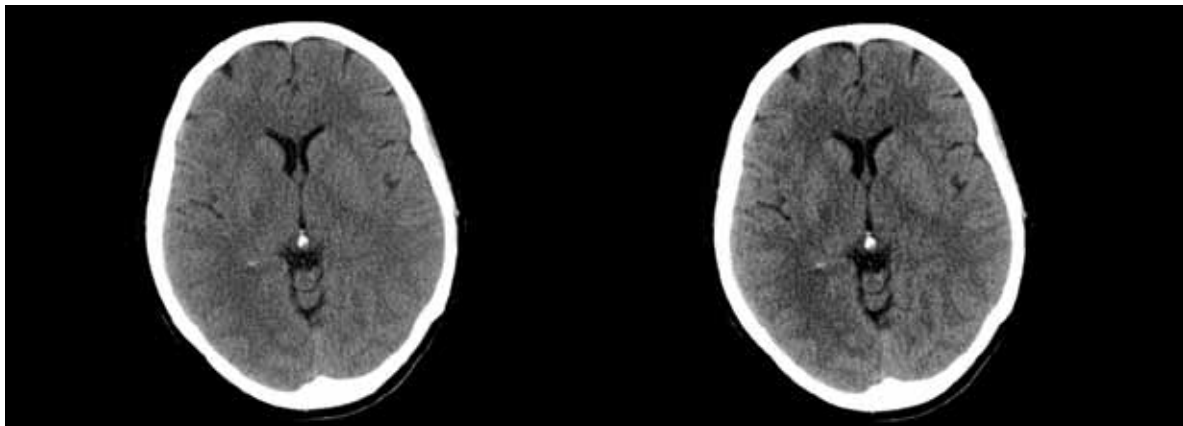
Conventional (left) and Neuro BestContrast-processed (right) non-contrast head CT images.
